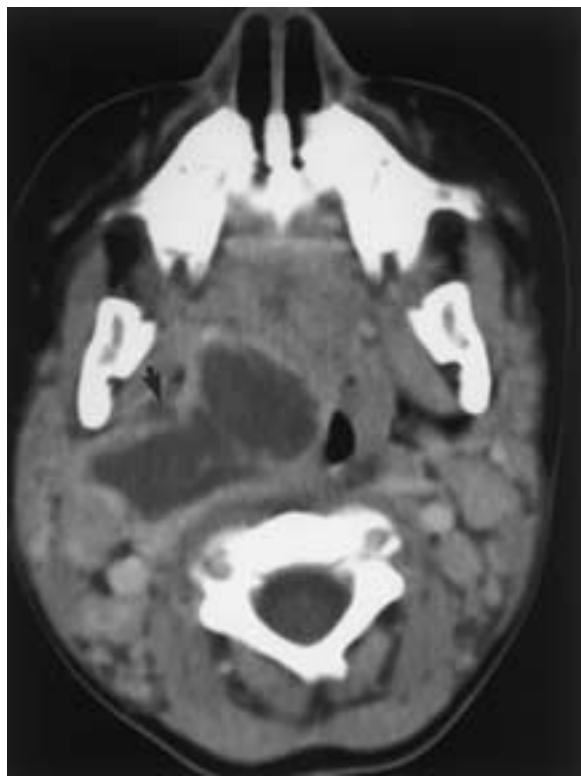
Large ruptured peritonsillar abscess in a 2-year-old girl with neck stiffness, fever, and poor oral intake. Contrast-enhanced CT shows a large right peritonsillar abscess that extends laterally and involves the parapharyngeal space (*arrow*).
